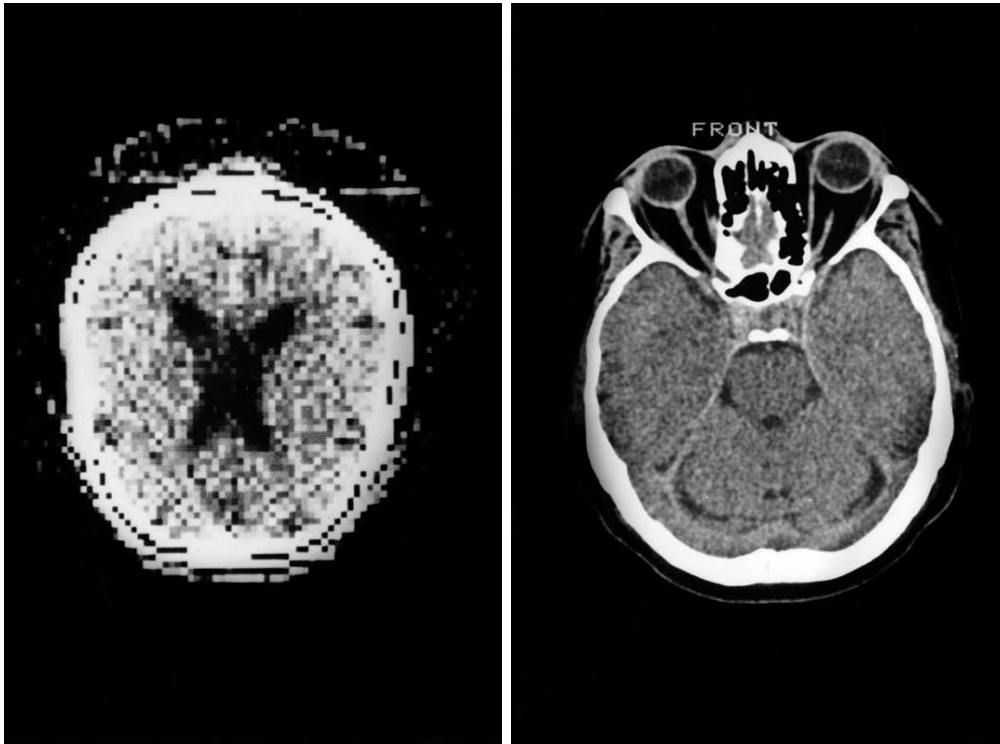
Cranial CT evolution: 1974 (left) VS 1983 (right) [11]
